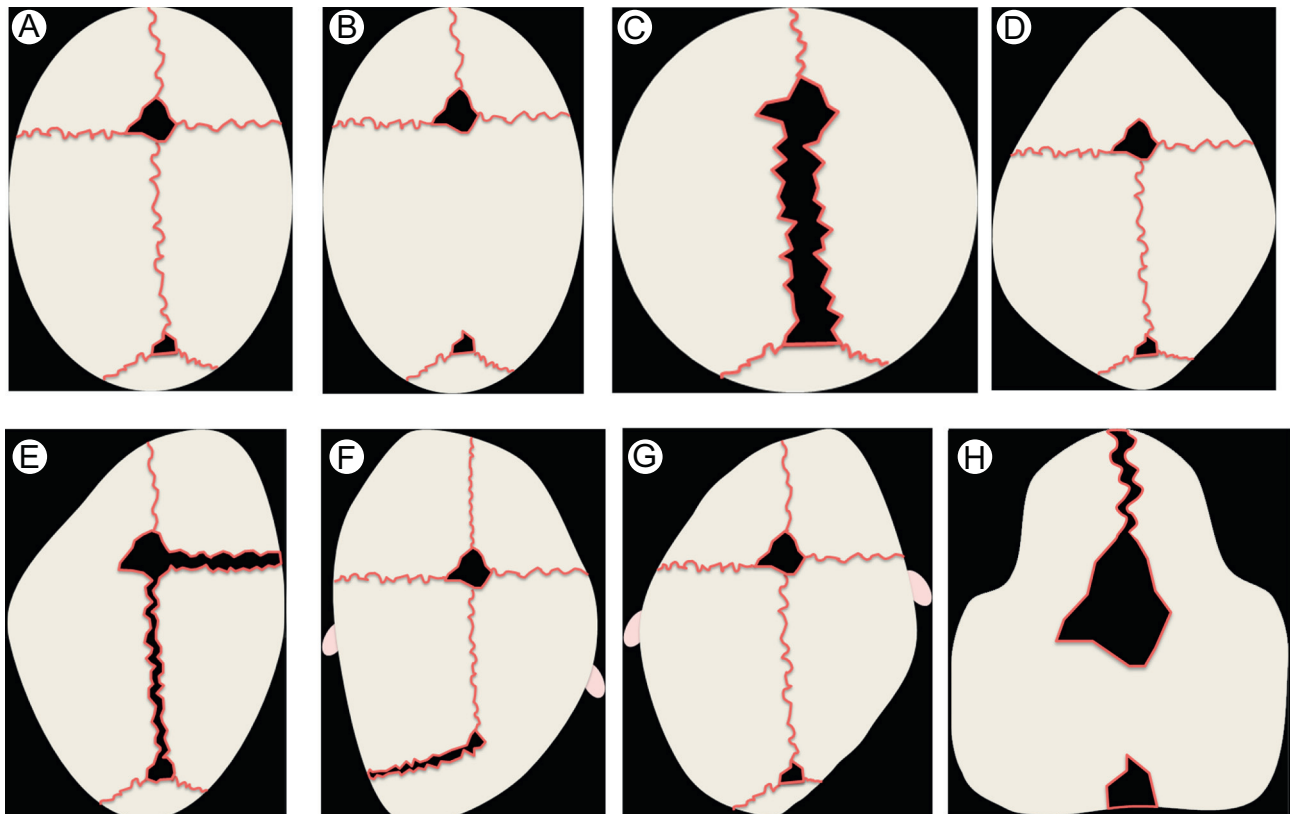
Characteristic calvarial morphologies as viewed from above, as would be seen in the course of a typical fetal ultrasound or MRI. With the exception of positional plagiocephaly, detection of one of these calvarial morphologies in the fetus is always abnormal and should raise suspicion for craniosynostosis. (A) Normocephalic, no synostosis present. (B) Scaphocephaly or Dolichocephaly, sagittal synostosis. (C) Brachycephaly, bicoronal synostosis. (D) Trigocephaly, metopic synostosis. (E) Anterior plagiocephaly, unicoronal synostosis. (F) Posterior plagiocephaly, unilambdoid synostosis. (G) Positional plagiocephaly, no synostosis present. (H) Kleeblattschädel, multisutural synostosis. (Color version of figure is available online.)
